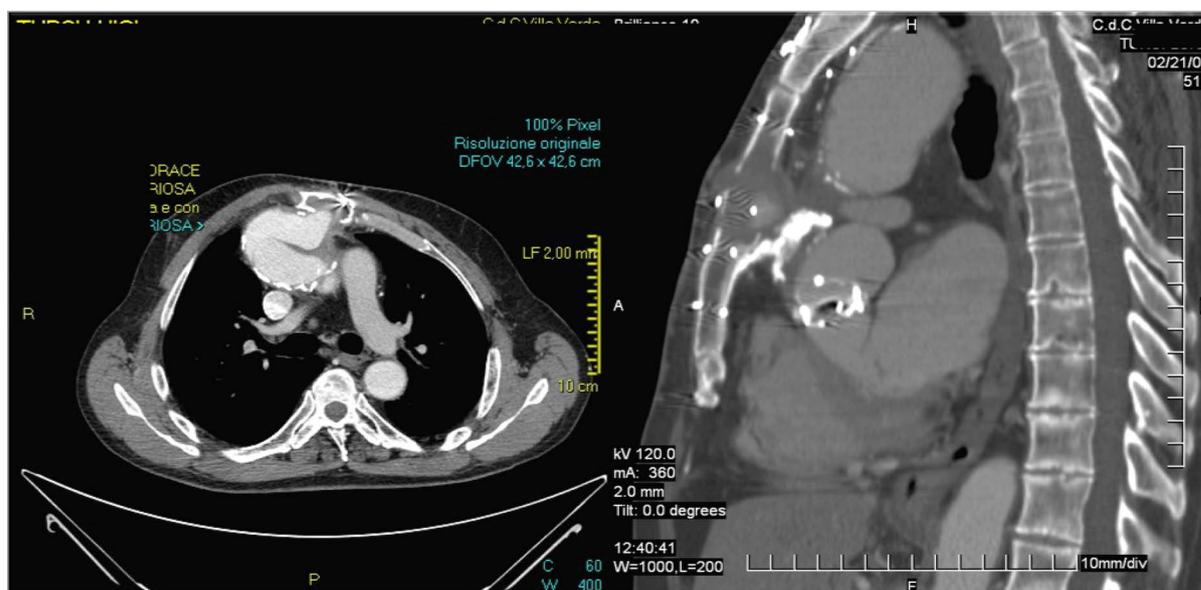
CT scan showing the giant pseudoaneurysm behind the sternum and the fistula protruding into the subcutaneous tissue.
